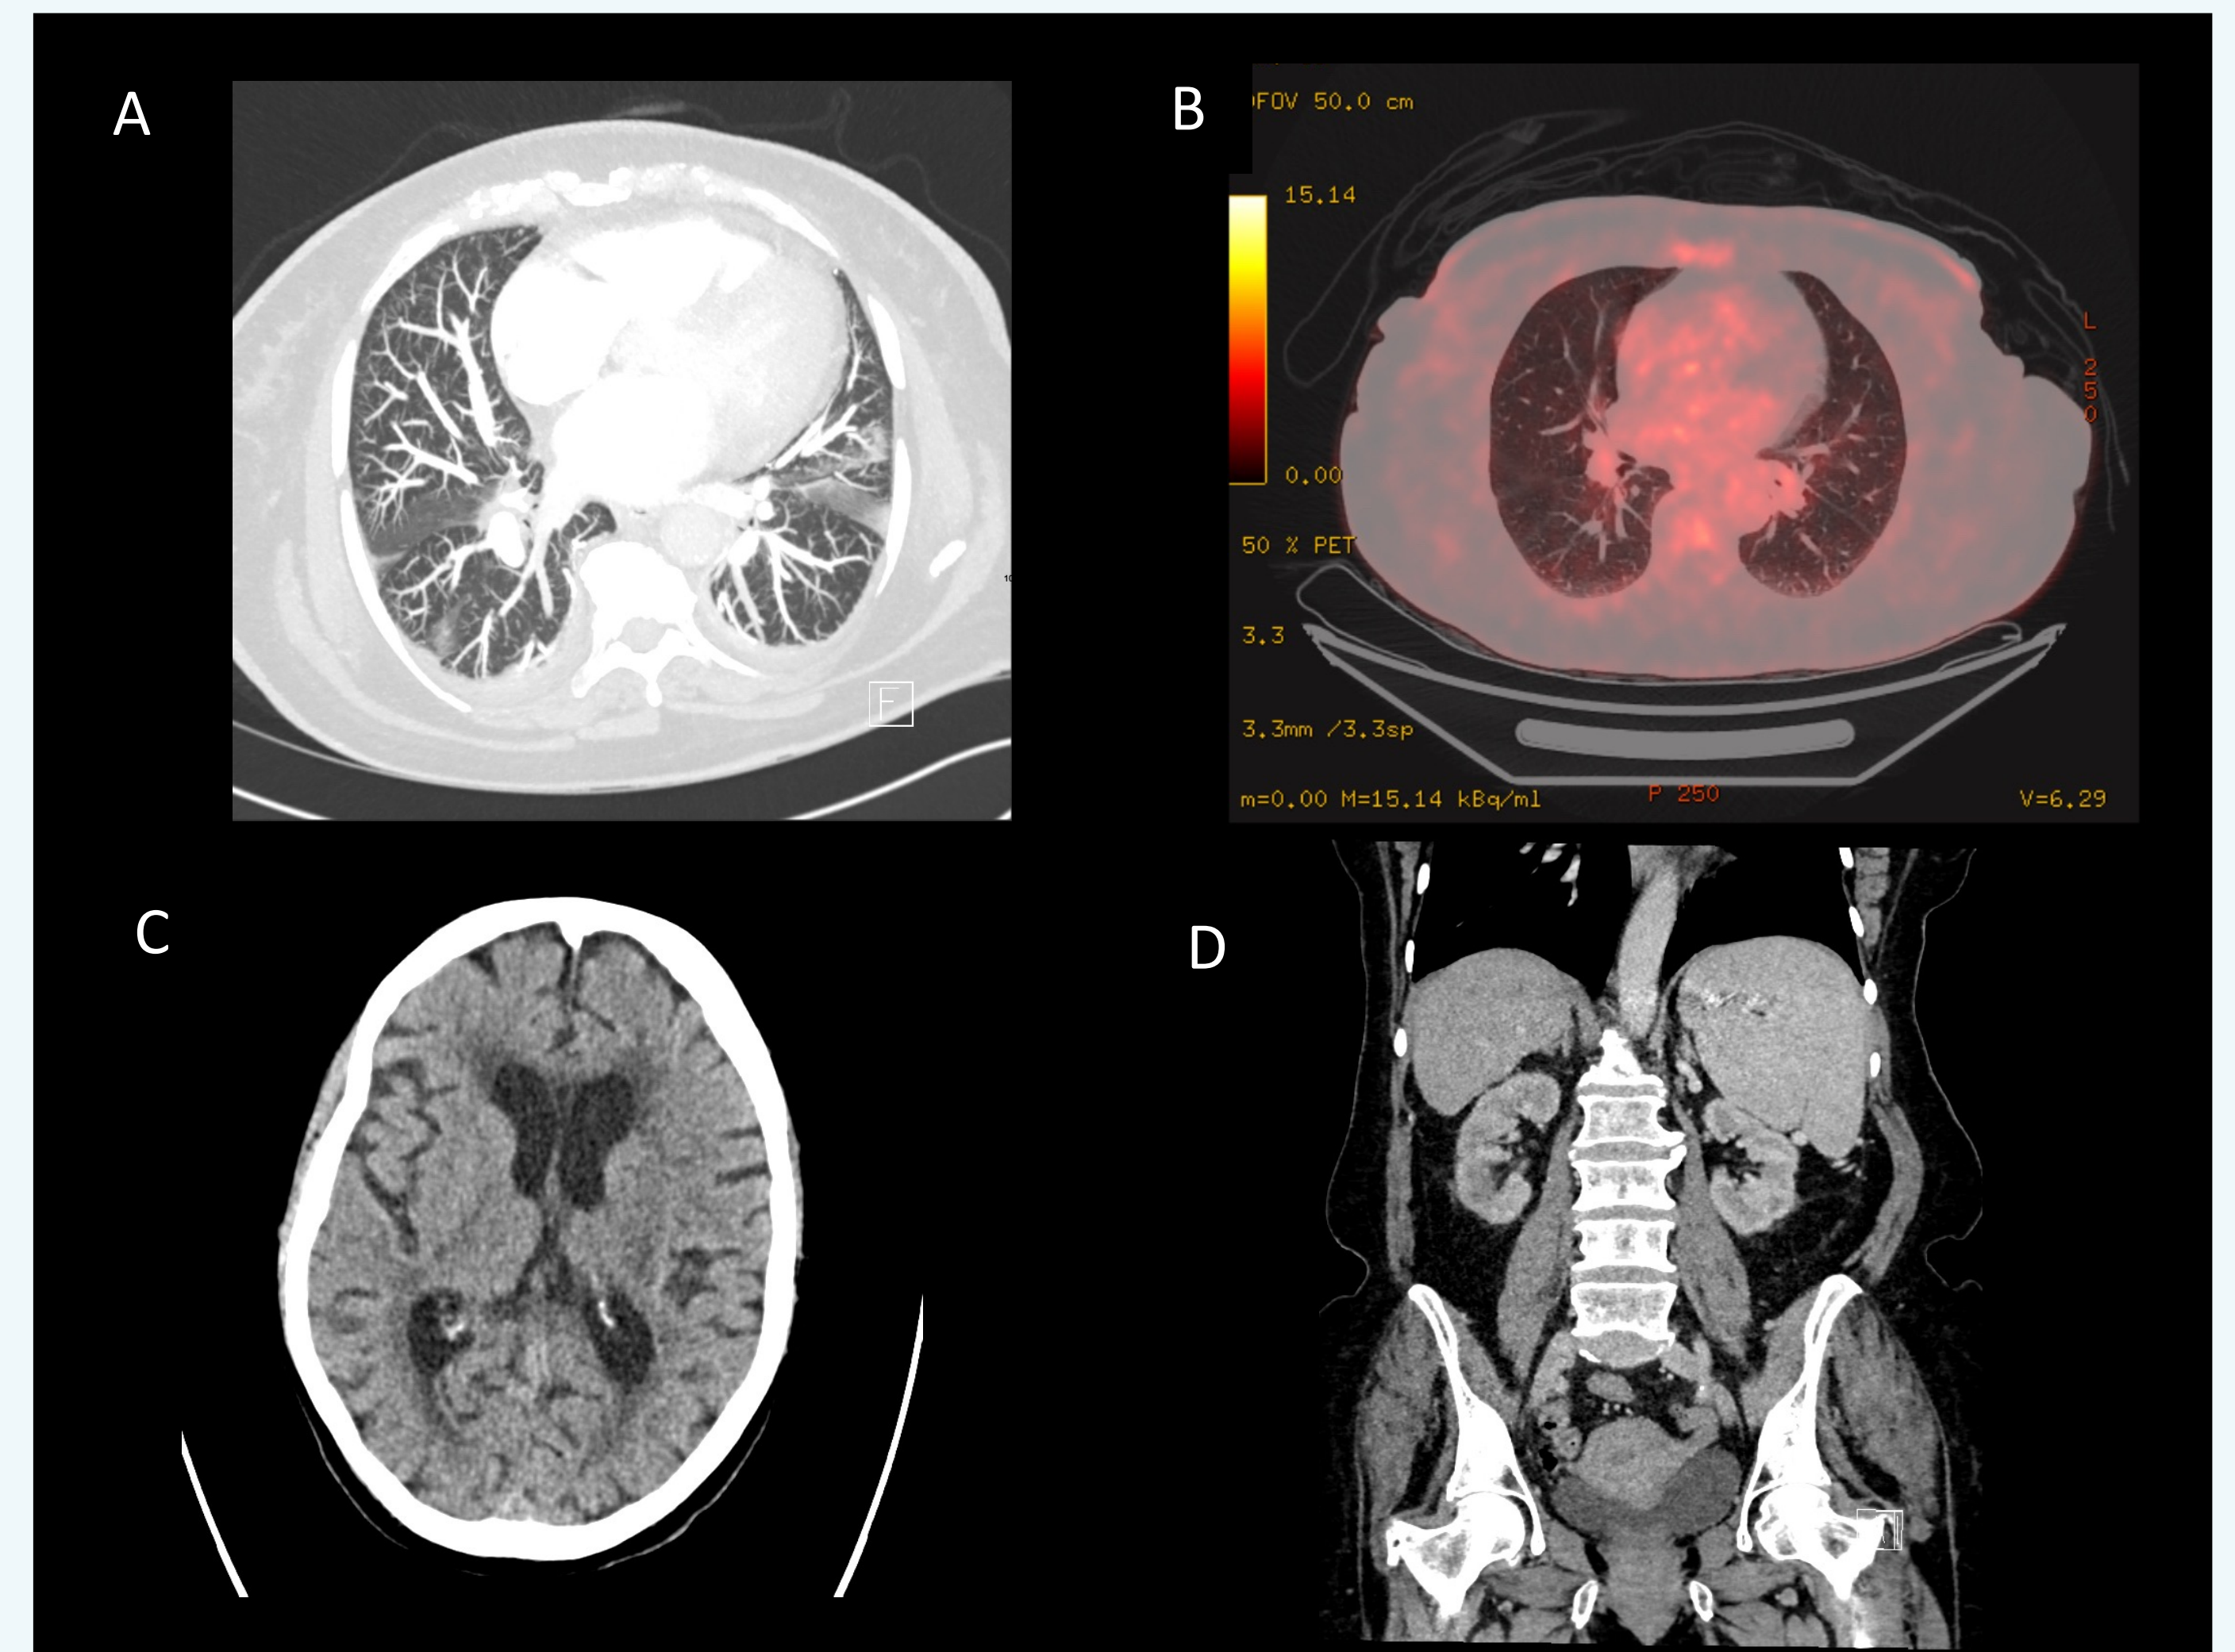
Radiological Investigations. (A) Atelectasis. (B) Normal PET-CT (C) No intracranial events. (D) No drainable abscess
